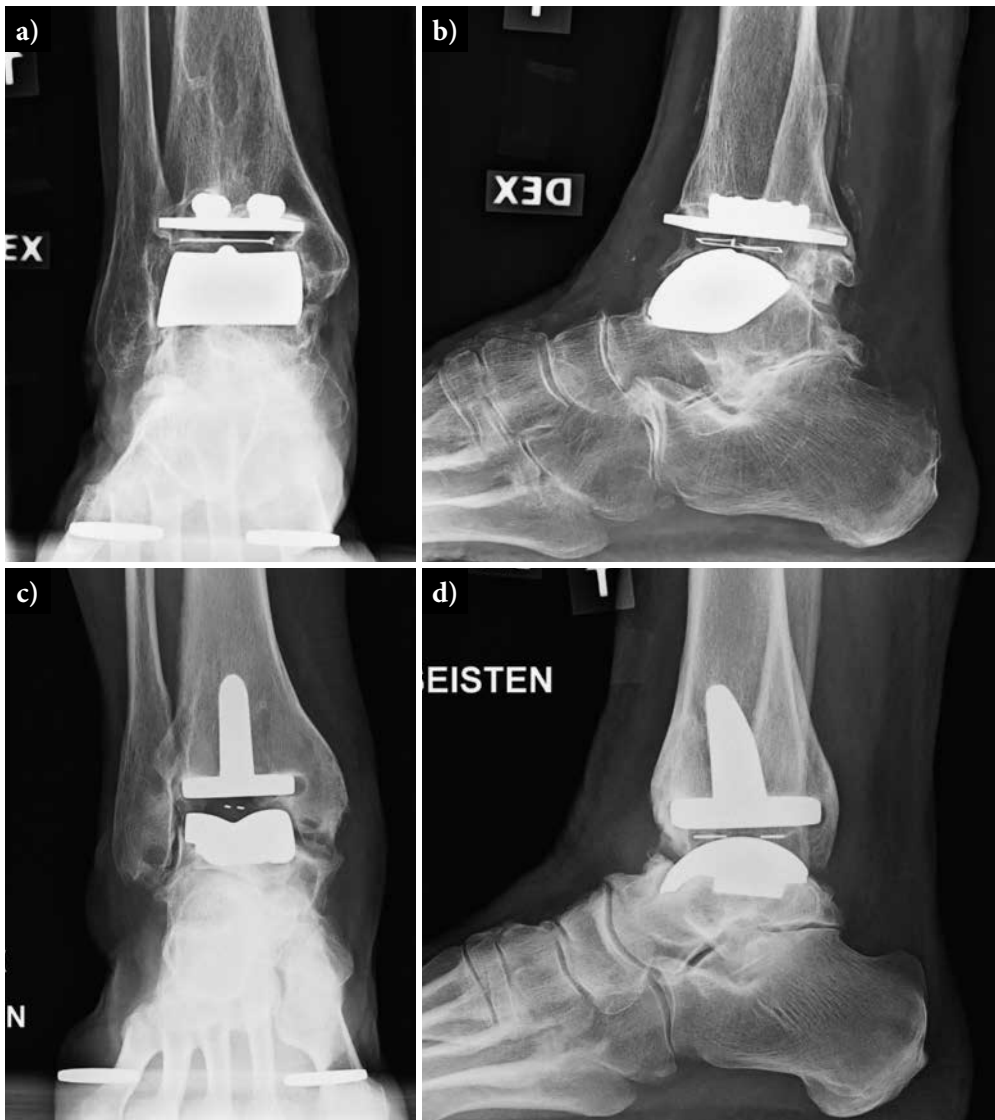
Radiographs of STAR (a and b) and AES prosthesis (c and d) in standing position.
